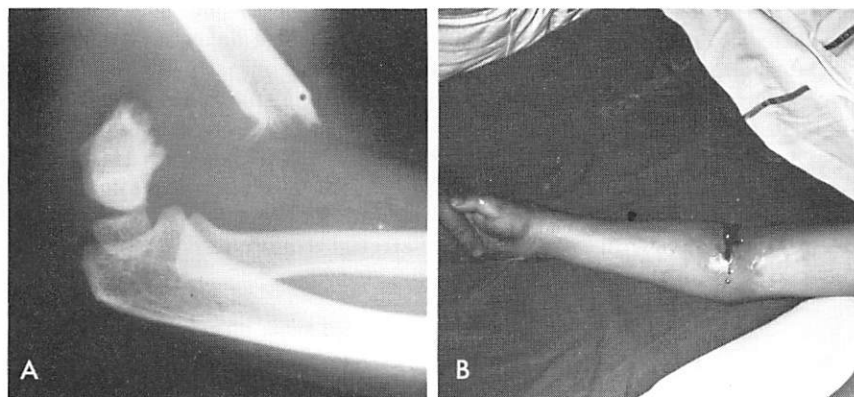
A severe posteriorly displaced supracondylar fracture of the humerus (A) has produced compartment ischemia. A radial pulse could be heard with the Doppler apparatus but was not palpated. The forearm was tense, swollen, and painful. Finger sensation was abnormal, and perfusion poor (B). Exploration revealed an intimal tear in the brachial artery. This was resected and replaced with a vein graft. A complete open forearm fasciotomy was performed.
